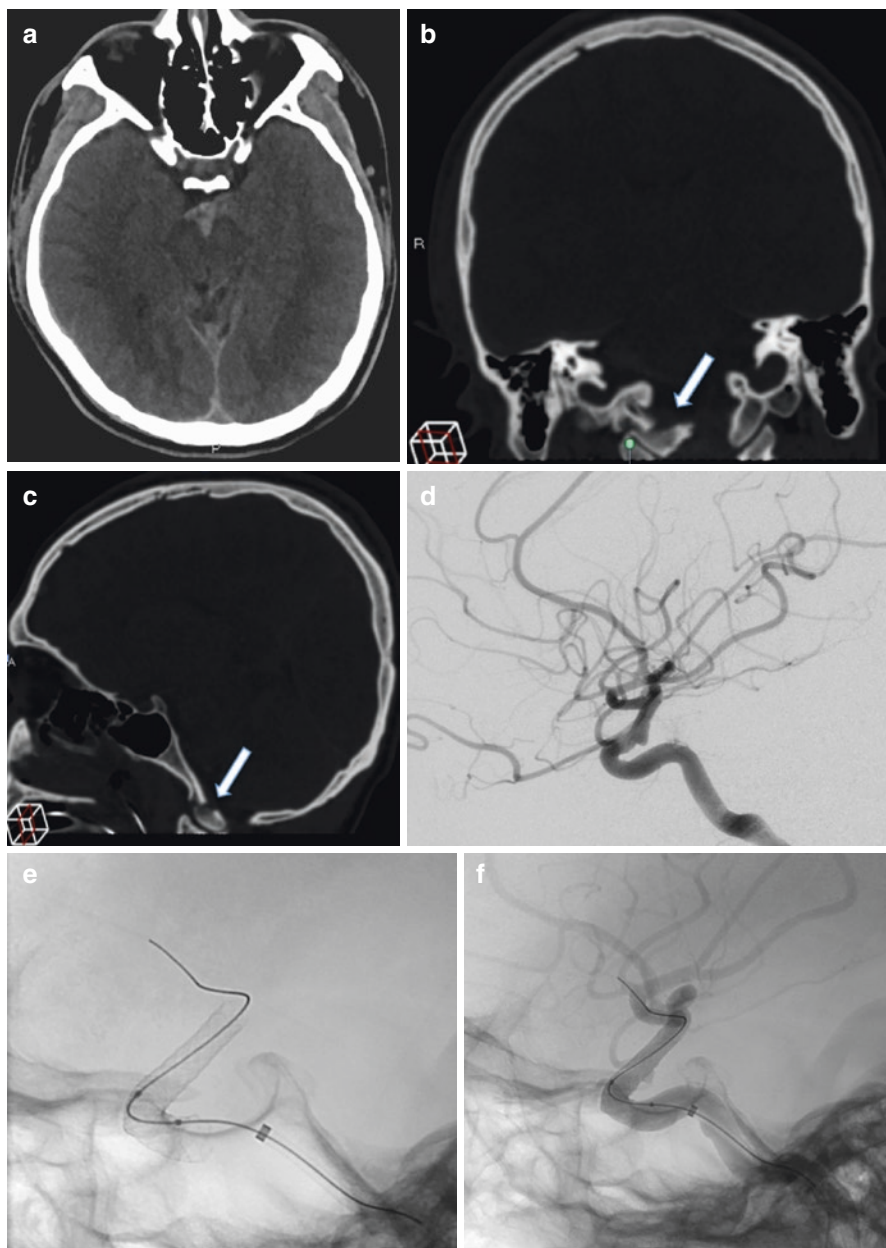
A 21-year-old patient with motor vehicle accident and severe head trauma. (a) Non-contrast head CT showing subarachnoid hemorrhage, especially perimesencephalic and along the tentorium. (b–c) Head CT in bone window, revealing a dislocated right occipital condyle fracture extending into the clivus (arrow). (d) Diagnostic cerebral angiography shows a traumatic blister aneurysm of the communicating segment of the right ICA. (e–f) A week later, second angiography verified the persistence of the aneurysm with no dissection flap visible. After deployment of two flow diversion devices across the blister aneurysm (e), flow reduction into the aneurysm can be observed (f)
